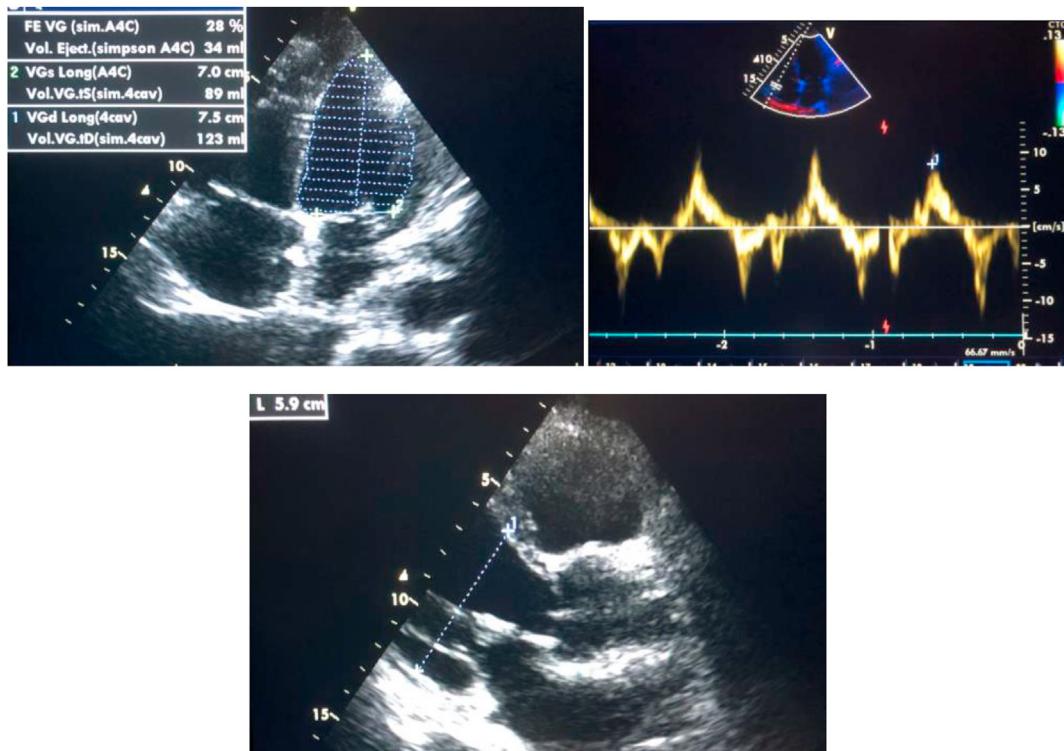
Transthoracic echocardiography showing a biventricular dilatation and the disappearance of the left ventricular thrombus.
